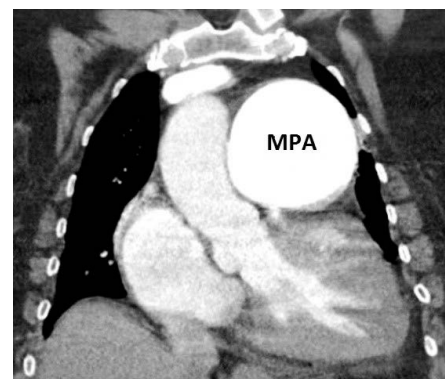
Chest computed tomography angiography, coronal view, demonstrating 7.4 cm main pulmonary artery (MPA).
